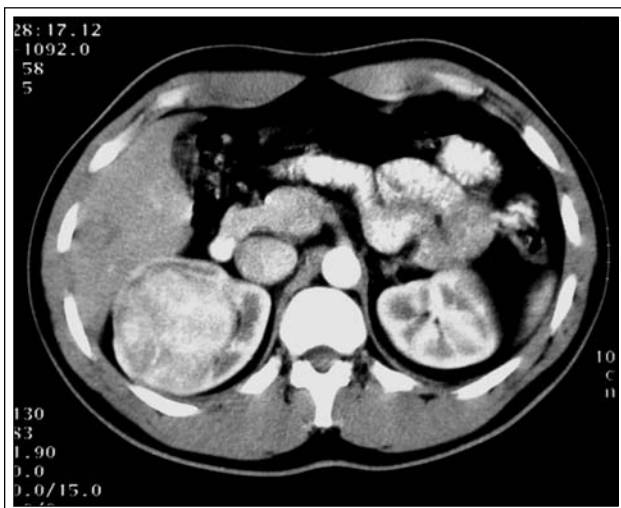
Contrast-enhanced computed tomography (CT) revealed a 7 cm x 5.8 cm x 4.5 cm well-circumscribed tumor at the upper and mid pole of the right kidney that consisted of hypodense, heterogeneous, and enhanced areas.
